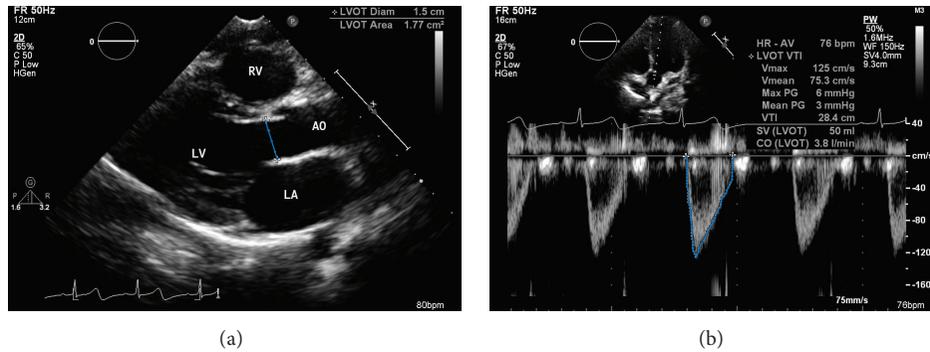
Stroke volume (SV) calculation. (a) Measurement of LV outflow tract diameter (LVOTD) using the parasternal long-axis view, and (b) use of pulsed Doppler for the measurement of velocity-time integral (VTI), as obtained in the 5-chamber apical view. Cardiac output (CO) = SV × HR; SV = VTI × LVOT area, where LVOT area = $\pi(\text{LVOT diameter}/2)^2$.
